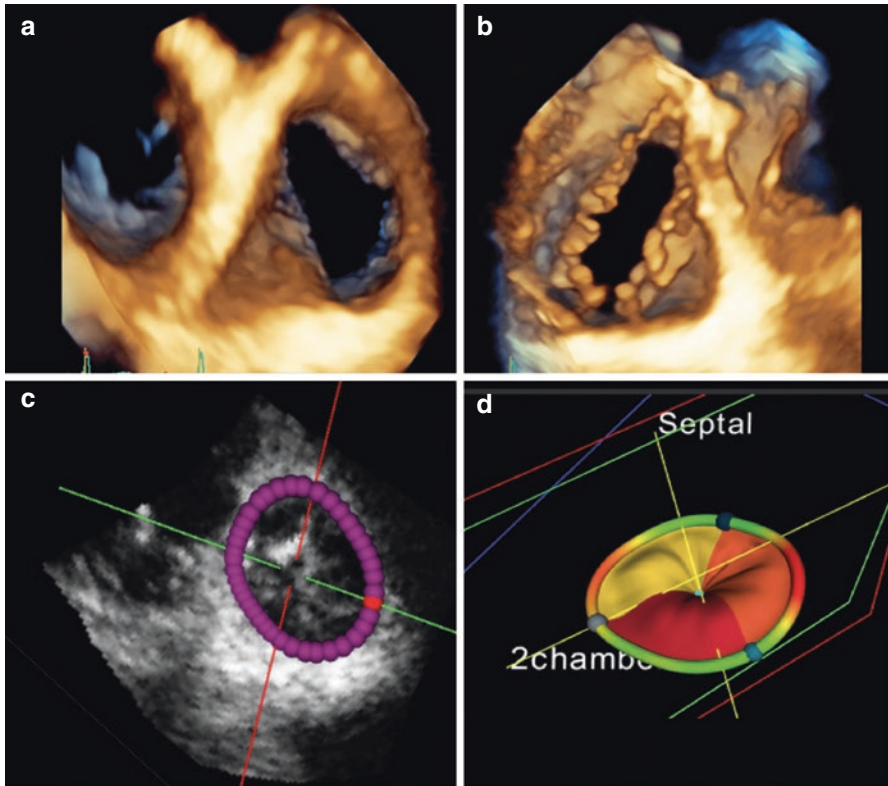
Tricuspid valve anatomy by transthoracic 3D echocardiography in a patient with functional tricuspid regurgitation, as seen from atrial (a) and ventricular (b) perspective. Using custom prototype software (courtesy of Federico Veronesi, University of Bologna, Italy), the tricuspid annulus (c, d) and leaflets (d) geometry can be semi-automatically quantified
